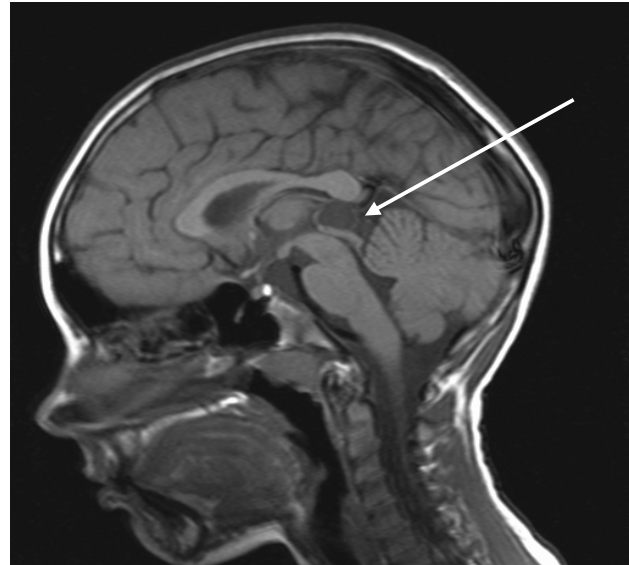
MRI of subject P.B., showing a cyst of the pineal gland
